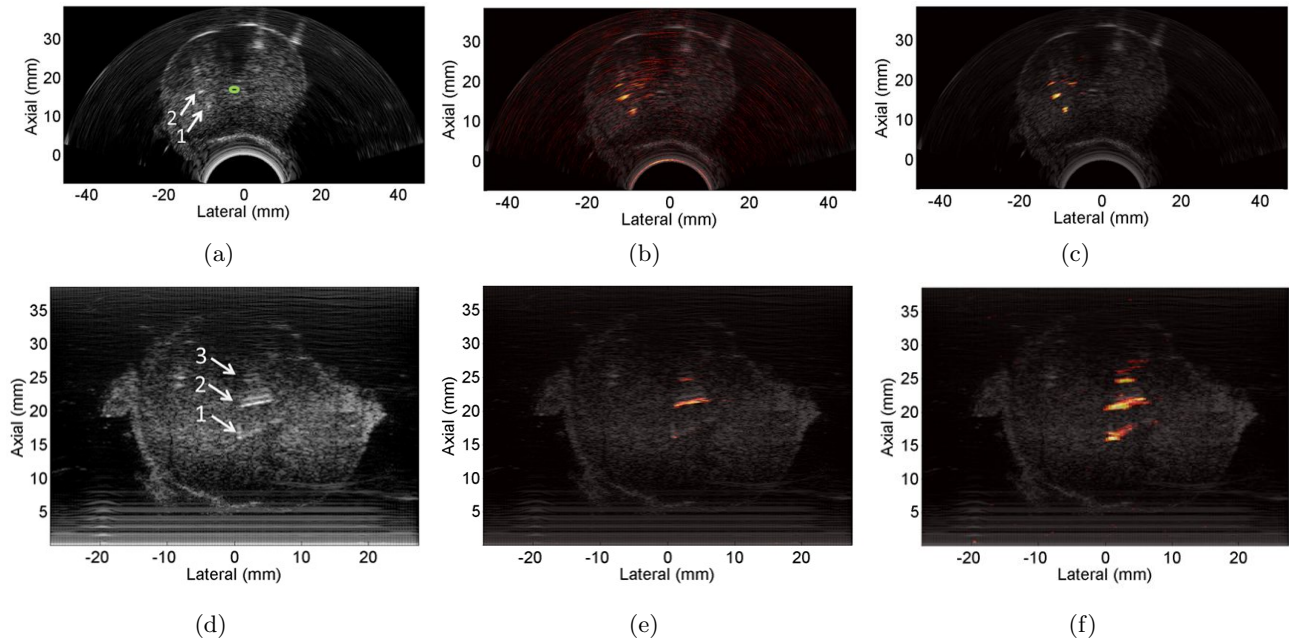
(a,d) Ultrasound images of brachytherapy seeds acquired with the curvilinear and linear ultrasound arrays, respectively. (b,e) DAS beamformed photoacoustic images acquired with the end-fire fiber and overlaid on the corresponding ultrasound images. (c,f) SLSC beamformed photoacoustic images acquired with the end-fire fiber and overlaid on the corresponding ultrasound images.
